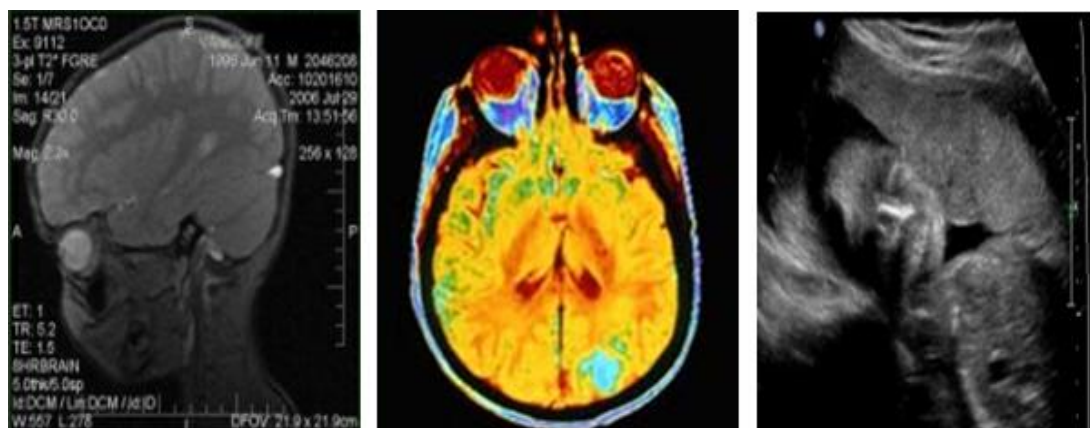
Examples of CAT (left), MRI (middle), and Ultrasound (Right) Imaging
